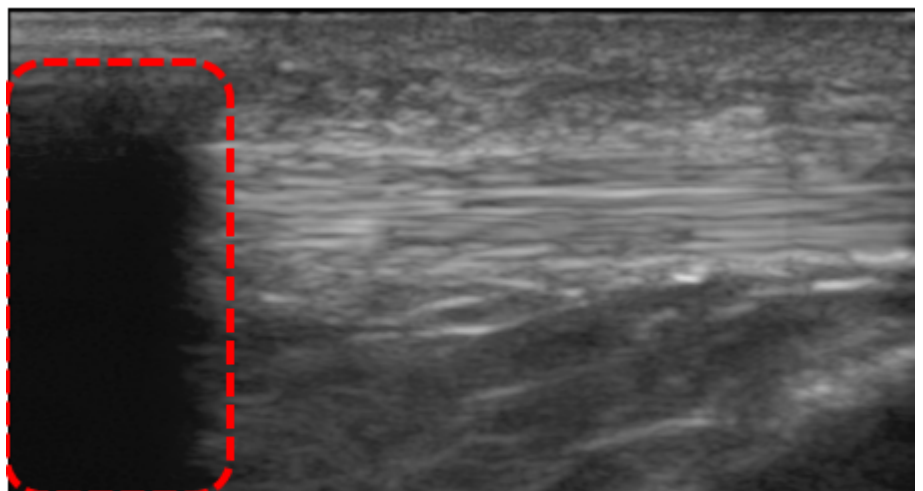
An ultrasound image of a tendon displaying a shadow (highlighted in red) due to detachment of the transducer
